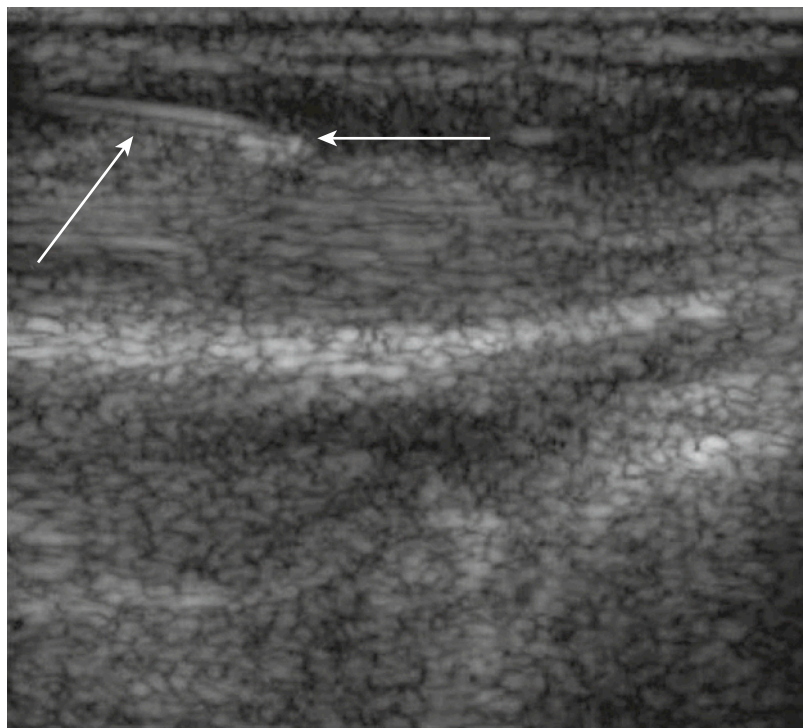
In ultrasound-guided injection of the tendon sheath, the shaft (*slanted arrow*) and tip of the needle are visible. The tip is located within the fluid-filled peroneal tendon sheath (*horizontal arrow*). The needle is parallel to the long axis of the transducer.
